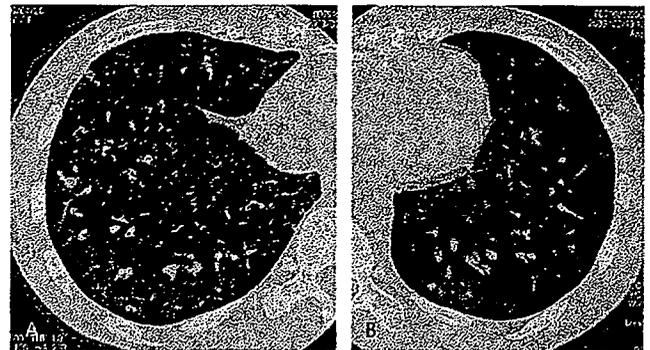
Mosaic perfusion or air-trapping are not seen in HRCT scan on expiration.
